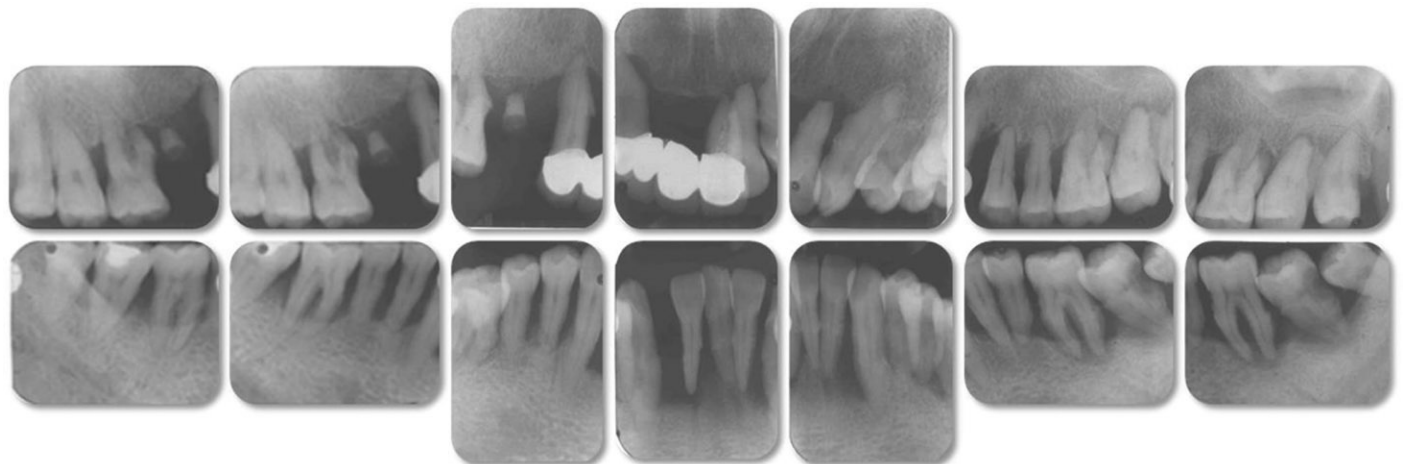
Initial full-mouth radiography.
